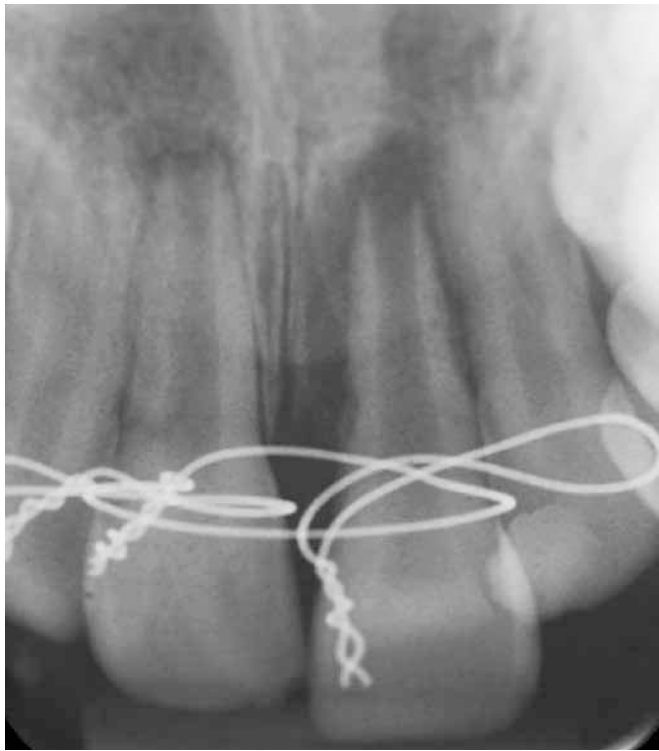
Initial radiography: It is observed immature teeth and external root resorption on the upper left central incisor.
